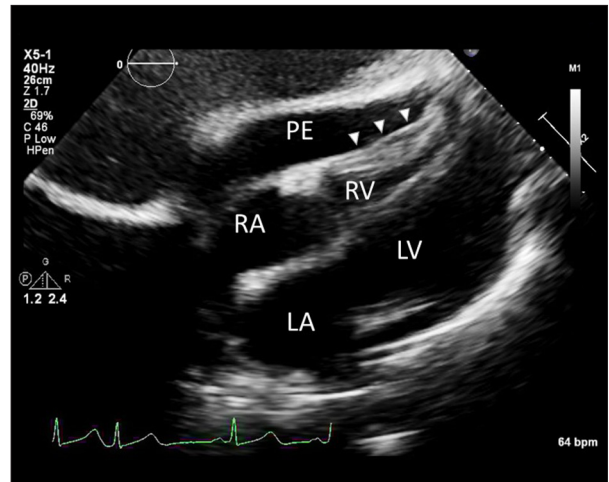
Echocardiogram. Subcostal view demonstrating large pericardial effusion and a mass (arrow) compressing the right ventricle. PE – pericardial effusion; RA – right atrium; RV – right ventricle; LV – left ventricle; LA – left atrium.
